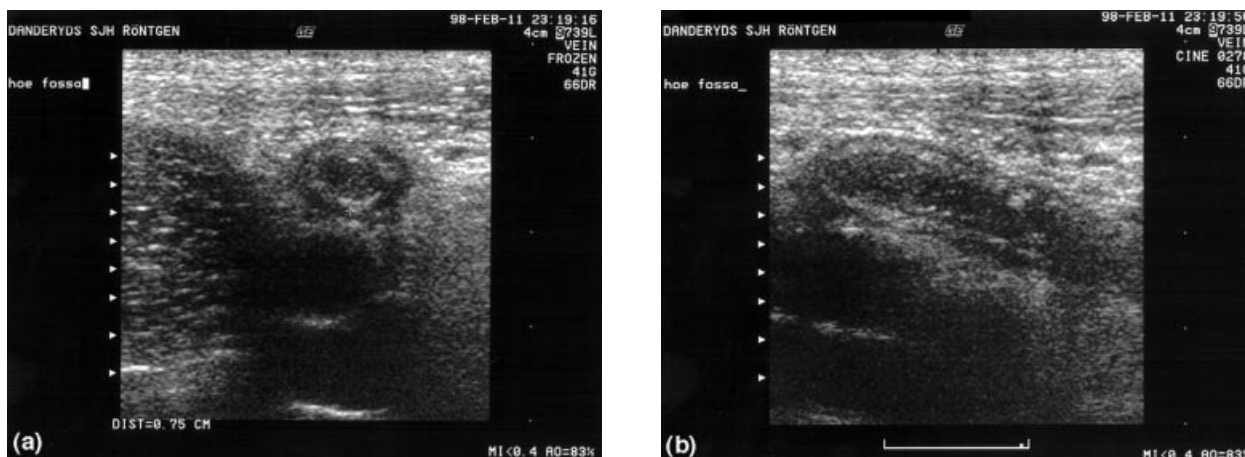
(a) Ultrasound examination. Sagittal section of the appendix. (b) Ultrasound examination in the same patient: longitudinal section of the appendix.
